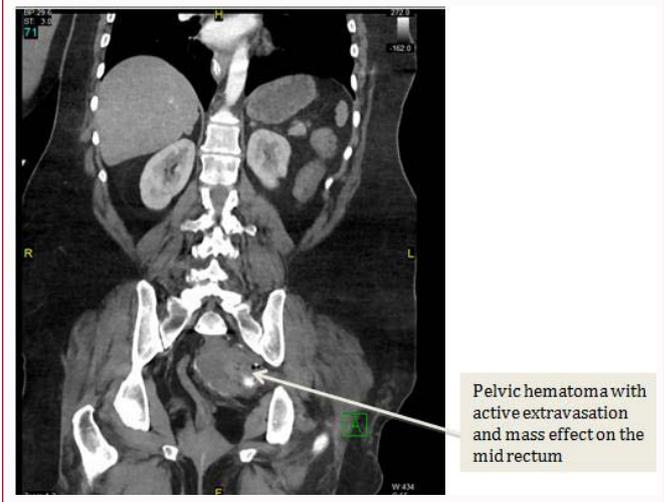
Abdominal CT revealing hematoma and extravasation along with mass effect on rectum.
